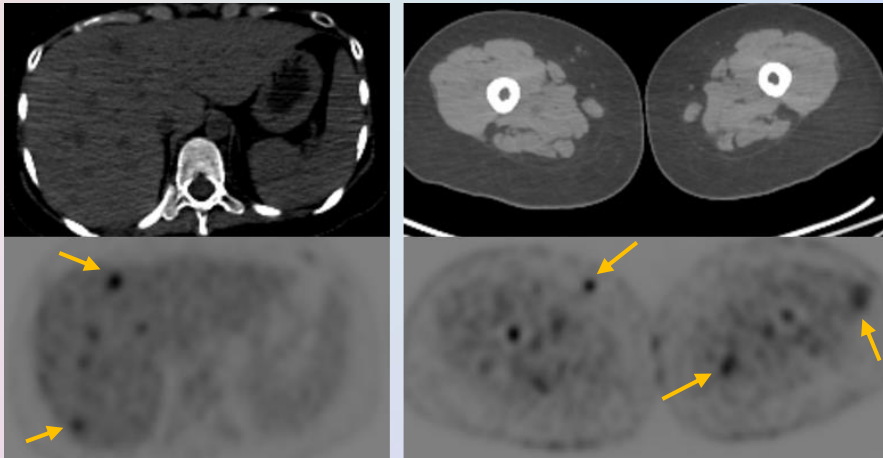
PET/CT showed multiple hypermetabolic lesions in the liver (arrows) and bilateral thigh intramuscular regions (arrows).
